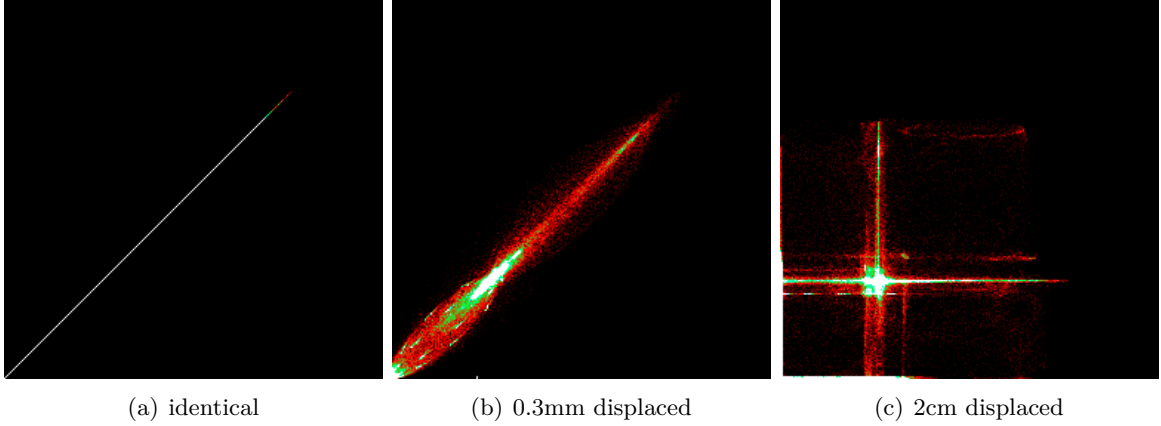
Joint histograms of a CT slice with itself, for various displacements.
